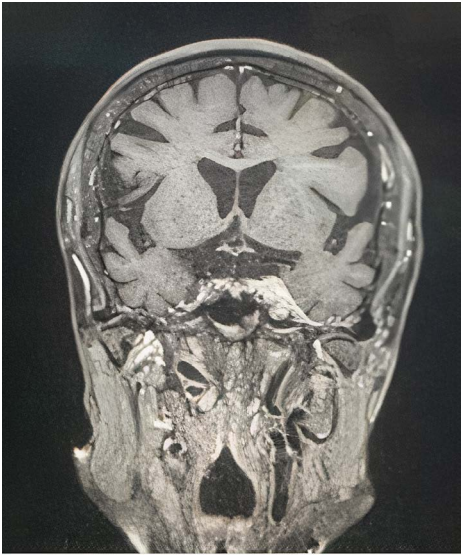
Magnetic resonance imaging showed a heterogeneously enhancing lesion in the left cavernous sinus.
